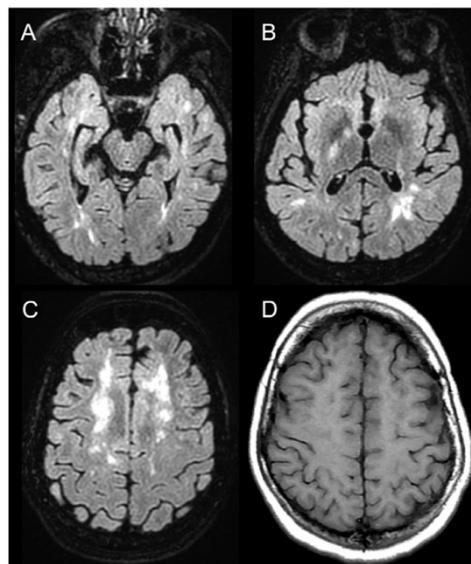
Repeat brain MRI after 44 months: axial FLAIR images (reconstructed from three-dimensional volumetric acquisitions) showing improvement in the hyperintense lesions (A, B, and C) and an axial T1-weighted image now showing no hypointense areas (D).
